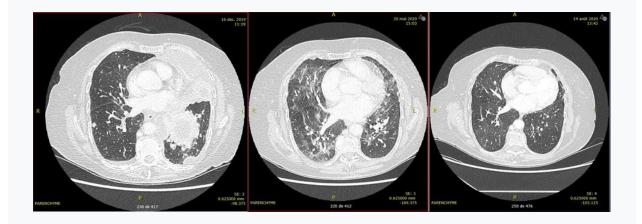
Parenchymal CT scan of Patient 1 before treatment with osimertinib (day 1), before anti-pneumocystis treatment (day 156), and after anti-pneumocystis treatment (day 242).
